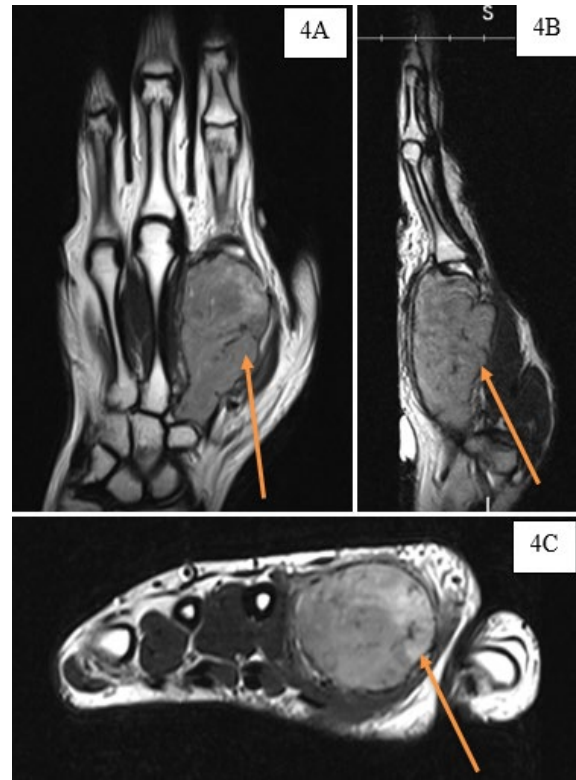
(Left). Pre-operative MRI. T1 coronal view (A), sagittal view (B), and transverse view (C) images were showing an expansile lesion with mixed-signal intensity.
